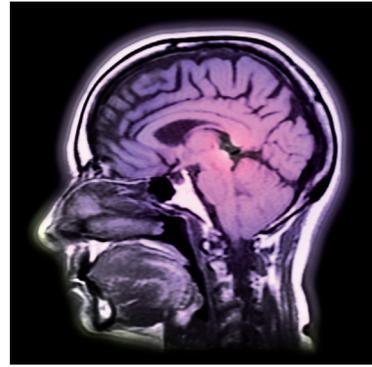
The great advantage of MRI is that it can display soft tissue, such as in this cross-section through a patient's head. (Image copyright: Dr James Holt.)
